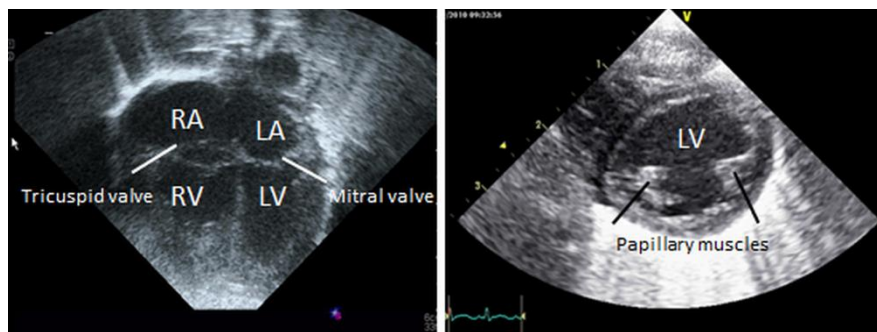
Standard 4 chamber and short axis views in a neonate: Ultrasound provides real time images of valve movement and wall motion. Measurements can then be taken to quantify contractility. The four chamber of the heart (right and left atria and ventricles (RA, LA, RV, LV)) can be seen clearly.
